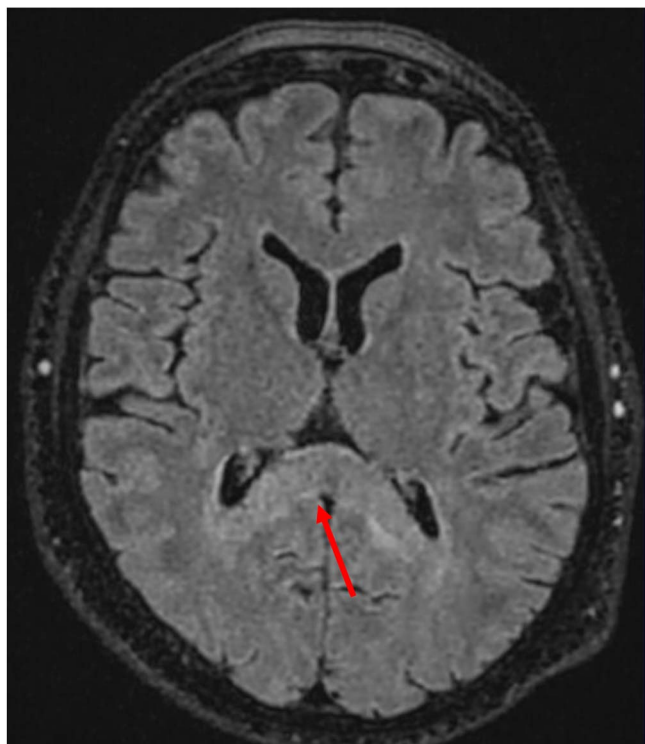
Sandwich sign follow-up MRI after 1 week.
